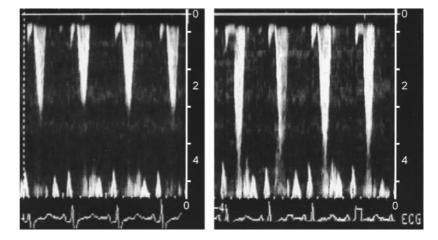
Pulsed wave Doppler representation of IIV before (A) and after (B) the Valsalva maneuver.
